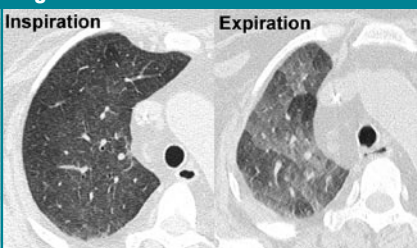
Transverse CT scans at end inspiration and end expiration show air trapping.
